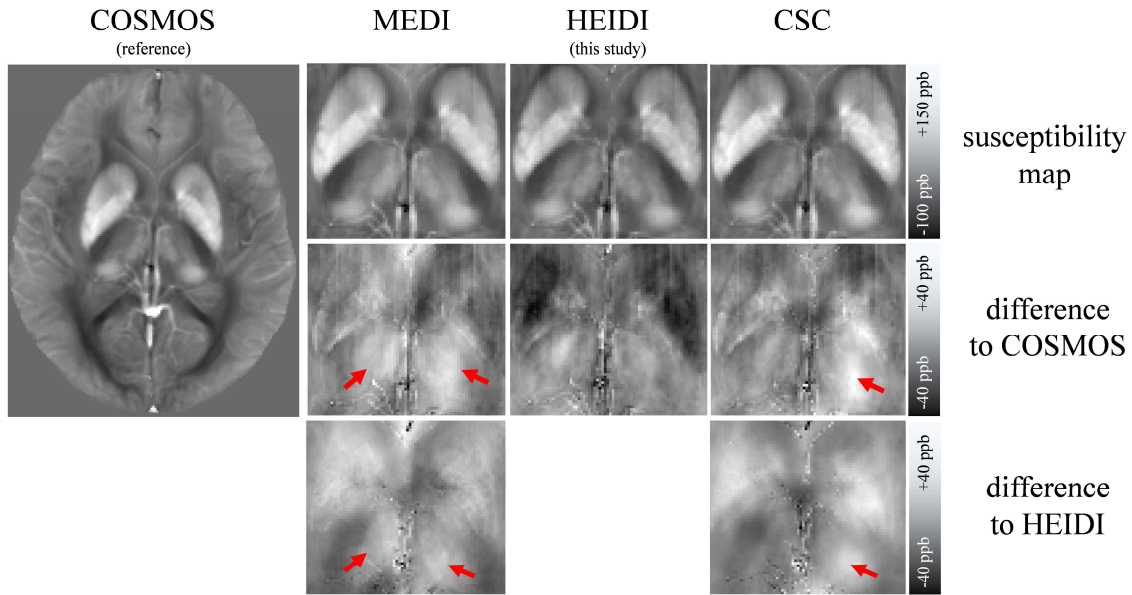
Comparison of the susceptibility reconstruction accuracy of different QSM algorithms in the thalamus based on the dataset generously provided by the Cornell MRI Research Lab (Yi Wang) at the Weill Cornell Medical College, NY. The dataset analyzed in this figure was used in a recent overview paper (Wang and Liu, 2015) and is available for download on the lab's website. The COSMOS algorithm (left), which relies on field maps acquired with the head at several different orientations relative to the main magnetic field, is commonly regarded as an *in vivo* gold standard. The MEDI algorithm (second from left) uses magnitude-derived anatomical priors for the susceptibility map calculation. The HEIDI algorithm (third from left) was used in the present study. The CS-compensated (CSC) algorithm (Wu et al., 2011) employs a CS-type approach without anatomical priors. The top row shows the susceptibility maps calculated with the individual algorithms. The middle row shows the differences relative to the gold-standard COSMOS susceptibility map. The bottom row shows the differences relative to the HEIDI susceptibility map. While providing accurate estimates of striatal susceptibility values, MEDI calculated substantially higher susceptibility values in the thalamus than COSMOS and HEIDI (red arrows), with clearly visible bi-hemispheric thalamic anatomy in the difference images. HEIDI had the lowest error in the thalamus, with only minor inhomogeneities in the difference image, but striatal susceptibility values were underestimated. The CSC algorithm ranked between HEIDI and MEDI. All images are mean value projections across the 17 slices covering the thalamus.
